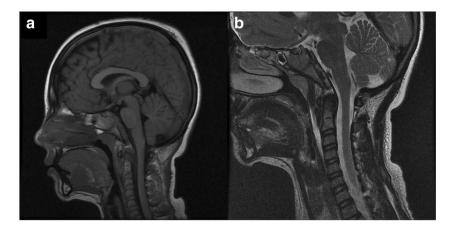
Sagittal T1-weighted (a) and T2-wieghted (b) MRI of the upper cervical spine. The tectorial membrane has been dissected 6 mm by a mixed signal mass that extends from the upper part of the clivus to the odontoid process corresponding with an epidural retroclival haematoma
